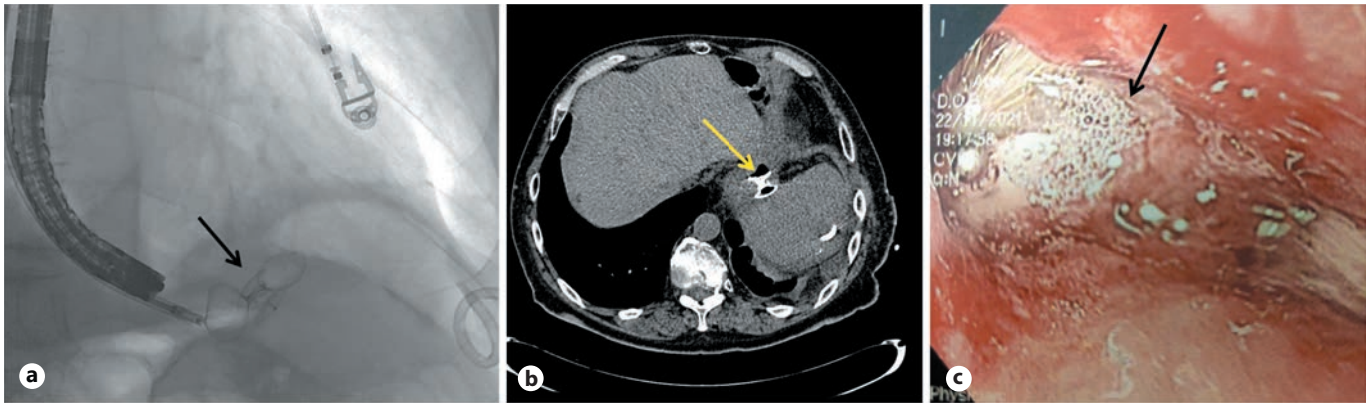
a Fluoroscopic image showing the first device positioned between the two (luminal and extraluminal) discs of the second one. b CT scan with both devices in place, with no extravasation of oral-administered contrast media. c Endoscopic visualization of both devices engrafted.
